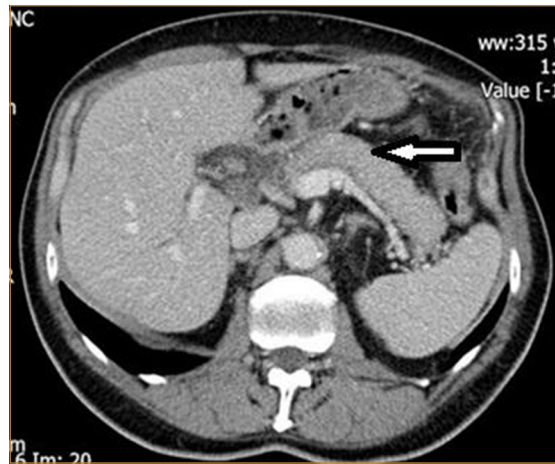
CT scan image with "Sausage shaped pancreas" (arrow)
